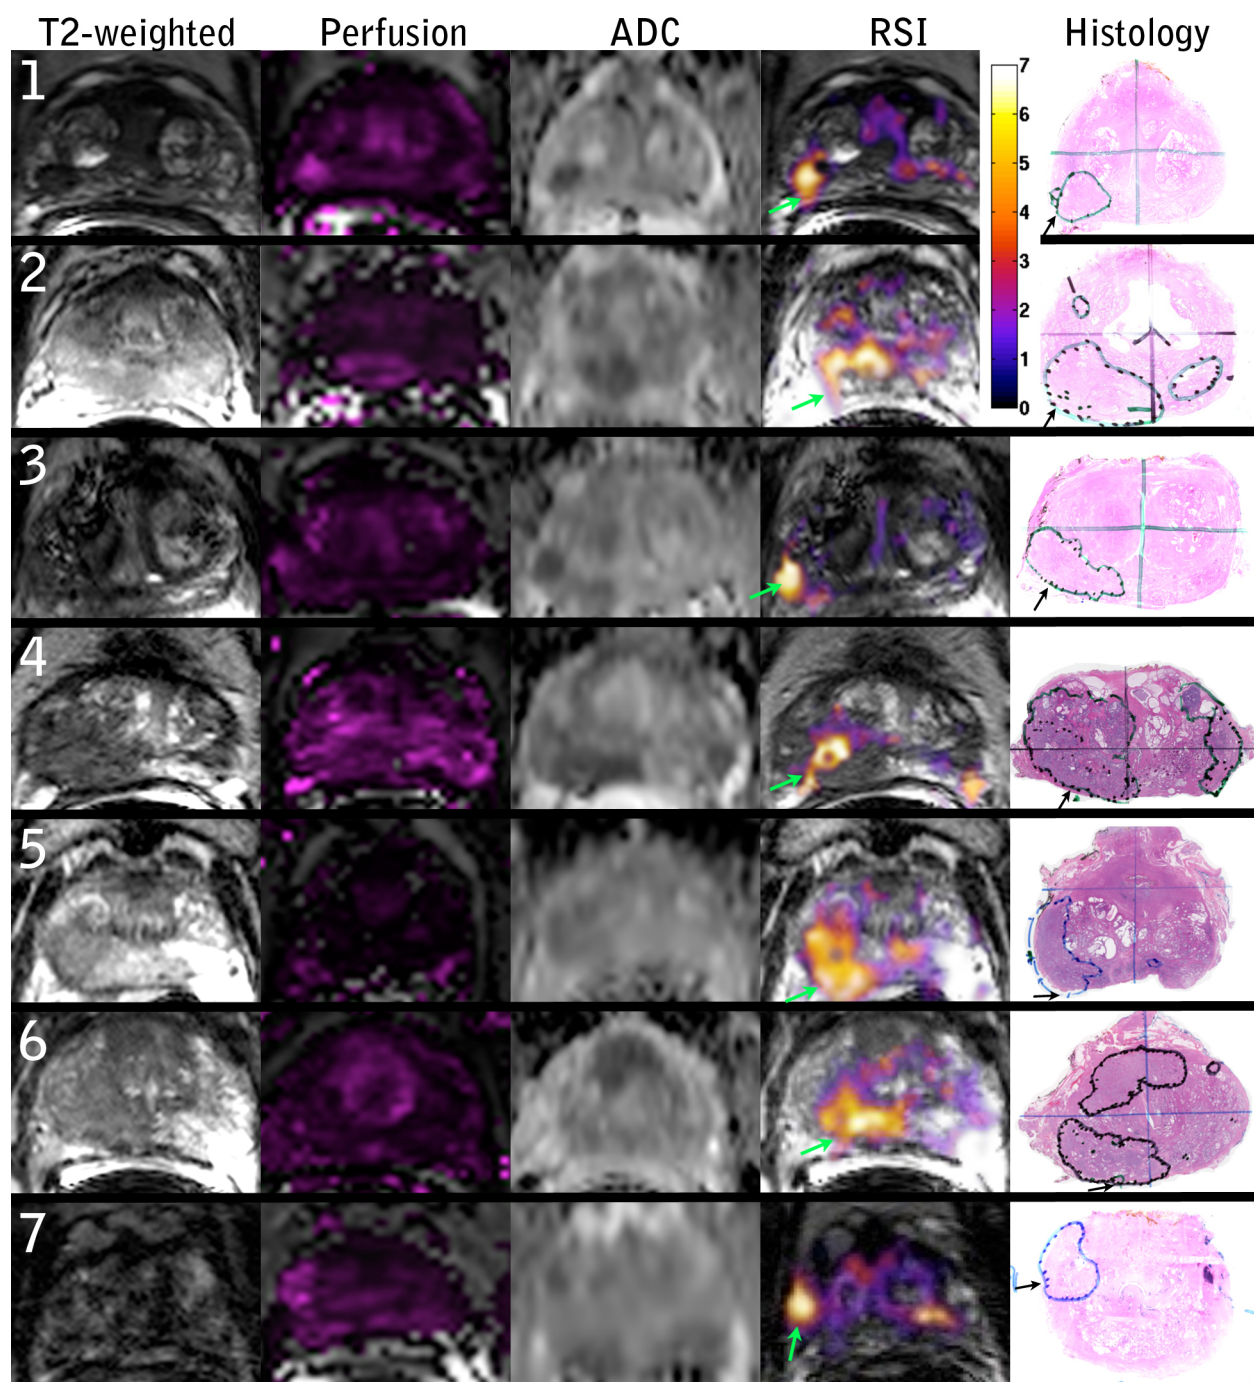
MR imaging and whole mount pathology for 7 prostate cancer patients with EPE. Column 1: T2 – weighted images, column 2: Perfusion K_{trans} maps, column 3: standard apparent diffusion coefficient (ADC) maps ($b = 0, 100, 400, \text{ and } 800 \text{ s/mm}^2$), column 4: RSI z-score maps, column 5: whole mount pathology with tumor and area of EPE identified. Color bar represents zscores from 0 to 7 for the RSI maps.
